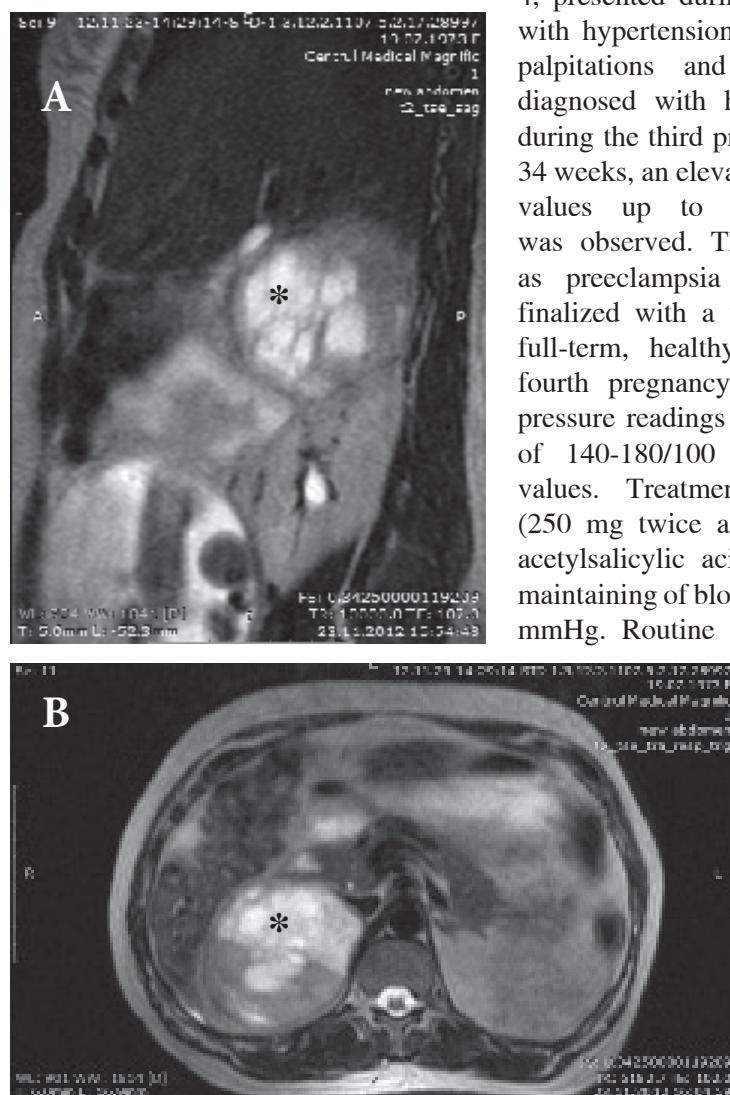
A, B. MRI images of the large right adrenal tumor* which compresses inferior vena cava. Note the internal septa on the sagittal view.
